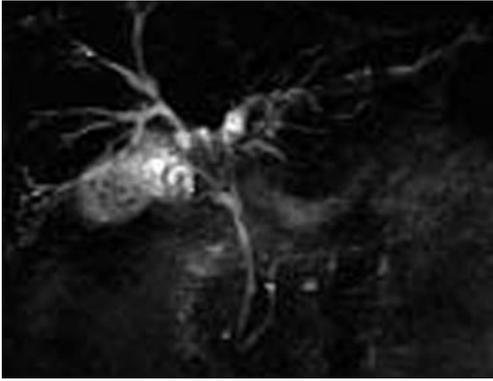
Primary sclerosing cholangitis in a 54-year-old man. Magnetic resonance imaging shows multifocal strictures and beading of the bile duct.
